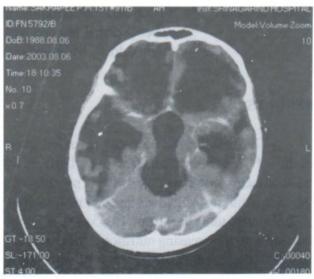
4L, 4M : Computed tomography brain scan revealed severe hydrocephalus with no evidence of tumour left in ventricles. (tumour dose 575 cGy/4 weeks)
